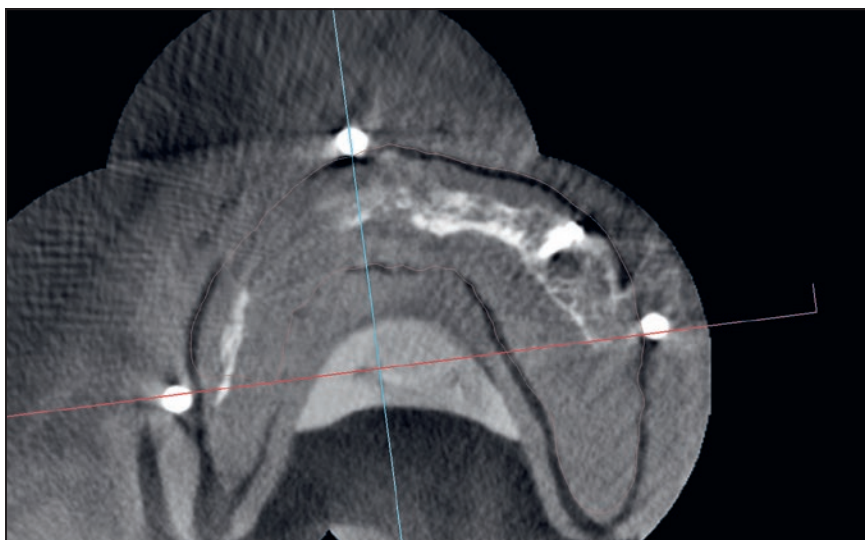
The radiopaque beads will be visible in the CT image. This will enable calibration of the wax-up and cast model STL files on the CT image.
